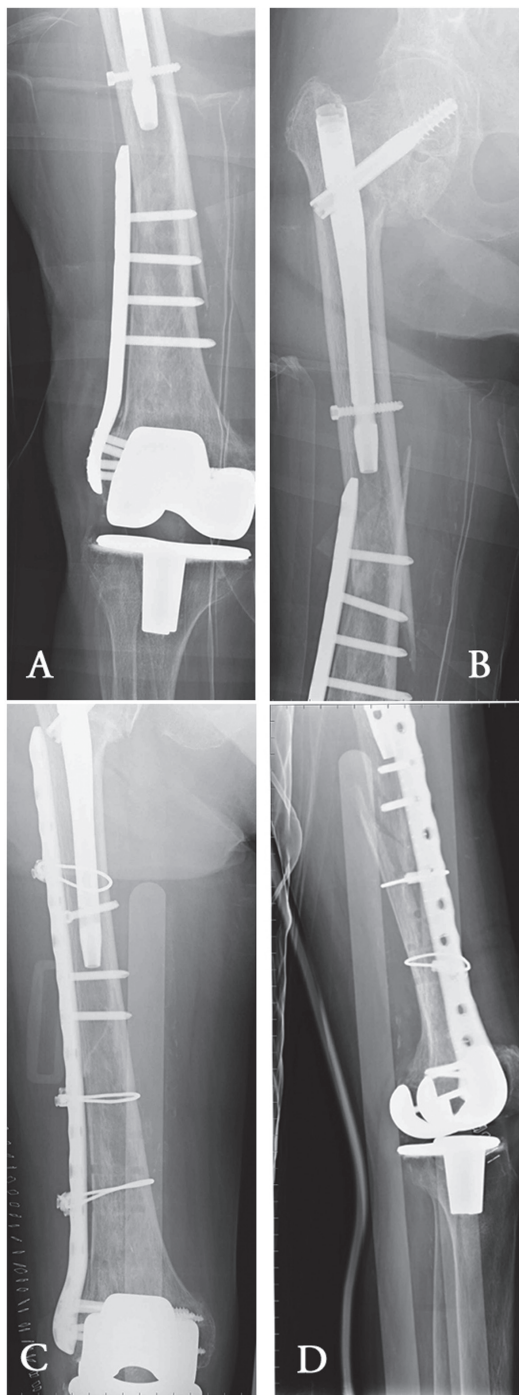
Femoral shaft fracture occurring between a too short locking plate implanted to treat a periprosthetic knee fracture and a previously implanted trochanteric nail in a 82 yrs old female patient. a, b) Radiographs showing the diaphyseal fracture between the two implants. c, d) AP and lateral x-rays obtained after plate removal, open reduction and new internal fixation with a longer locking plate sufficiently overlapping with the intramedullary nail to avoid stress raisers
